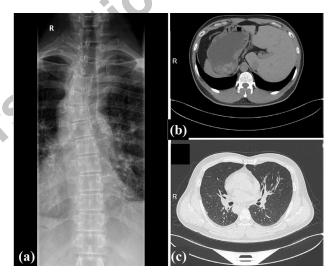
Clinical features of patient. (a) Radiographic image of patient with bronchiectasis showing right left-sided lumbar scoliosis (b and c) The chest high-resolution computed tomography (HRCT) scan of patient showing bronchiectasis and the situs inversus.
